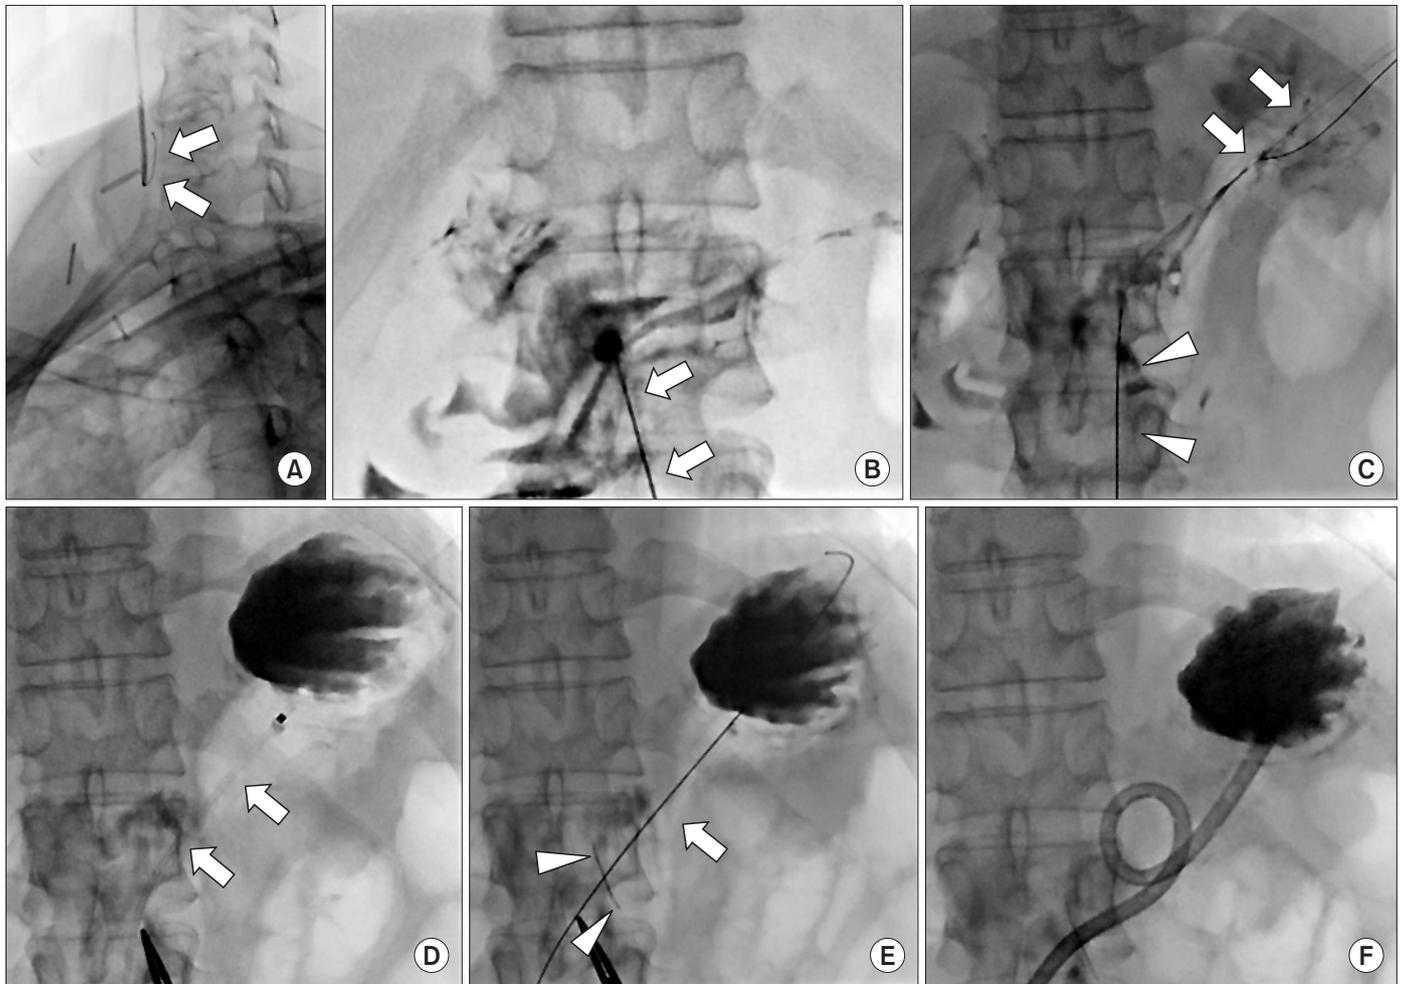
Placing a gastrostomy tube in patient with nondistended stomach due to complete esophageal obstruction. (A) Passing a guidewire (arrows) through the stricture is impossible. (B) A Chiba needle (arrows; Cook, USA) is used to puncture the nondilated stomach under ultrasonographic guidance (not shown). Contrast is injected through the Chiba needle, and the image shows the spread of contrast medium in the nondistended stomach. (C) Insertion of a 0.018" microguidewire (arrows) via the Chiba needle (arrowheads) into the stomach. (D) Insertion of a 6-Fr Neff catheter (arrows) over the microguidewire. The stomach is air-inflated through the Neff catheter (Cook). (E) The anchor (arrowheads) is pushed with a 0.035" guidewire (arrow) through the Neff catheter. The Neff catheter is subsequently removed. (F) Gastrostomy catheter is successfully inserted after serial dilation of the tract.
